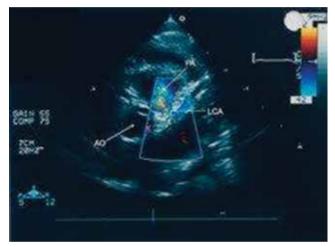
Color Doppler examination in the parasternal short-axis view demonstrating the left coronary artery (LCA) arising from the pulmonary artery (PA). AO: aorta
